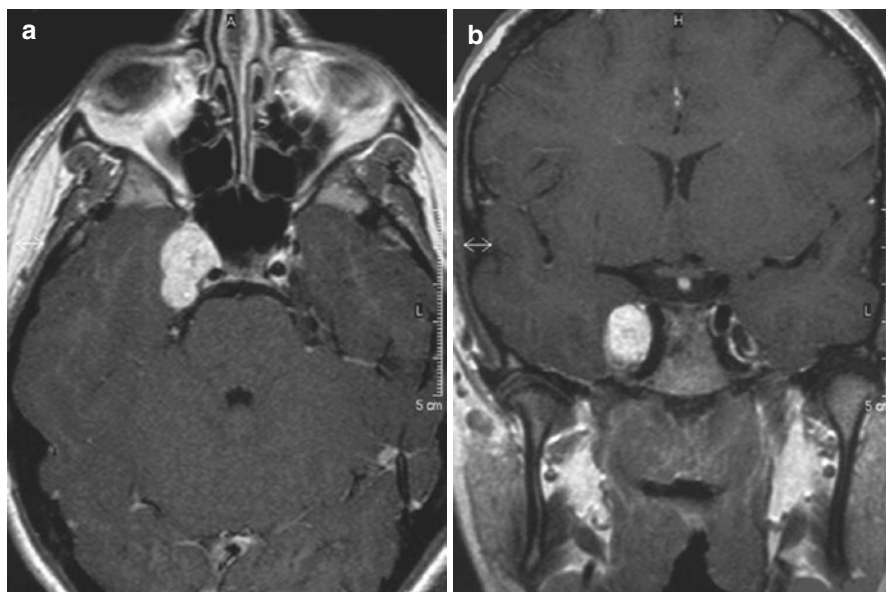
T1 weighted enhanced MRI (a) axial and (b) coronal images showing a large lesion adjacent to the cavernous sinus on the right side, which is expansile but not associated with meningeal enhancement or “tail”
